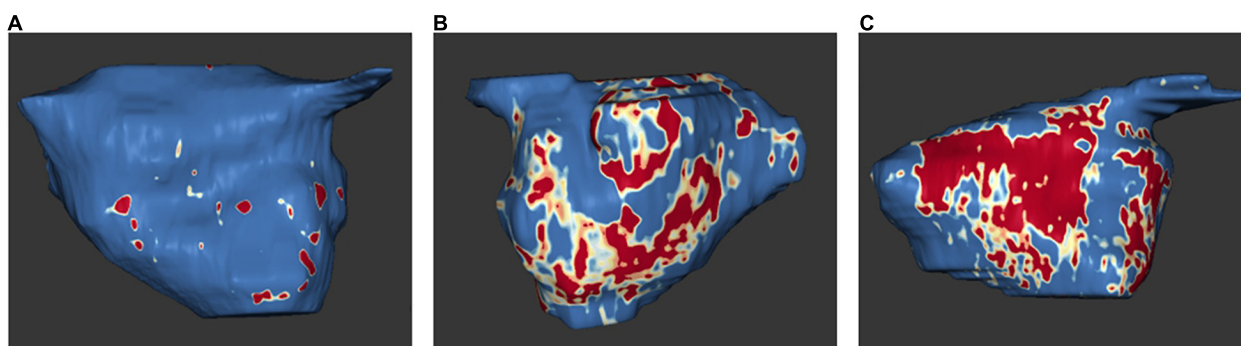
Examples of MRI examinations of the left atrium: left atrial tissue fibrosis based on 3D delayed enhancement magnetic resonance imaging scans. Normal left atrial wall is displayed in blue, fibrotic changes are in red and white. Amounts of fibrosis as a percentage of the total left atrial wall volume. (A) Utah stage 1 (1%). (B) Utah stage 3 (27%). (C) Utah stage 4 (36%). With the friendly support of Dr. Misagh Piran (Herz- und Diabeteszentrum Nordrhein-Westfalen, Ruhr-Universität Bochum).
